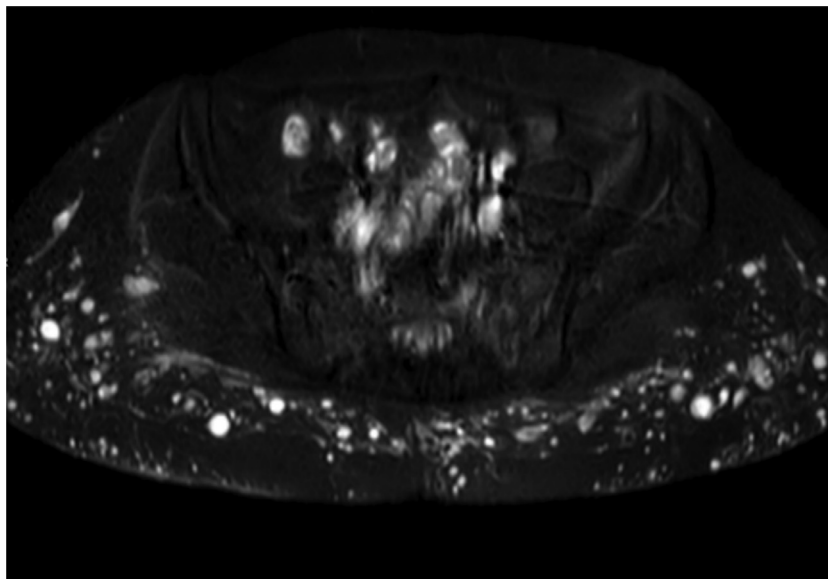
An example of a silicone selective (“silicon-only”) axial MR image of the pelvis revealing the subcutaneously injected liquid silicone as multiple hyperintense foci.
